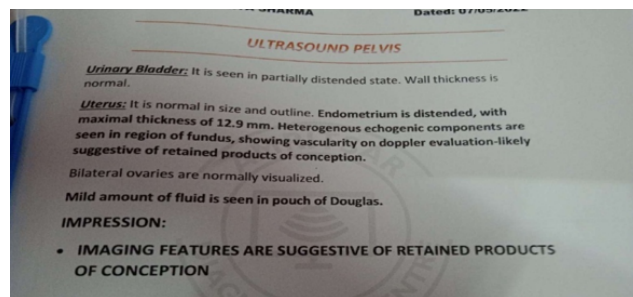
Showing the ultrasound report of the patient
